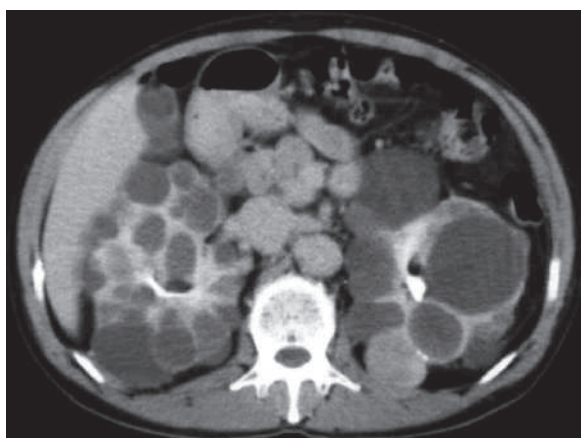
Axial CT urography image in a patient with ADPKD shows bilateral mildly enlarged kidneys with multiple cysts
